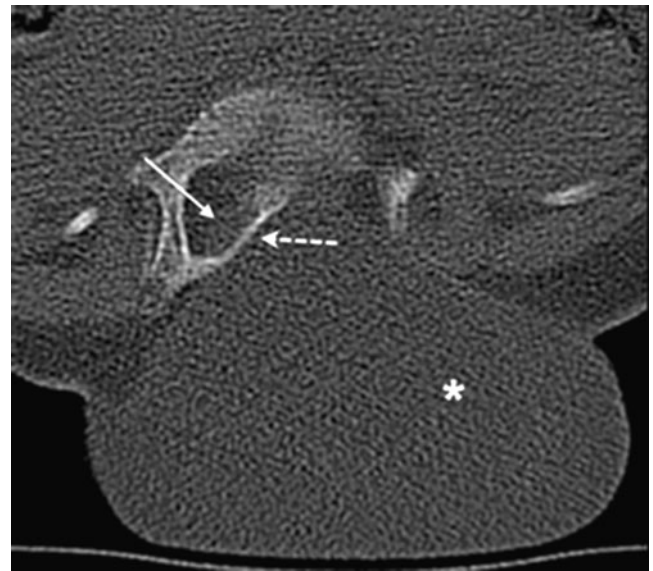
Axial low-dose CT image
